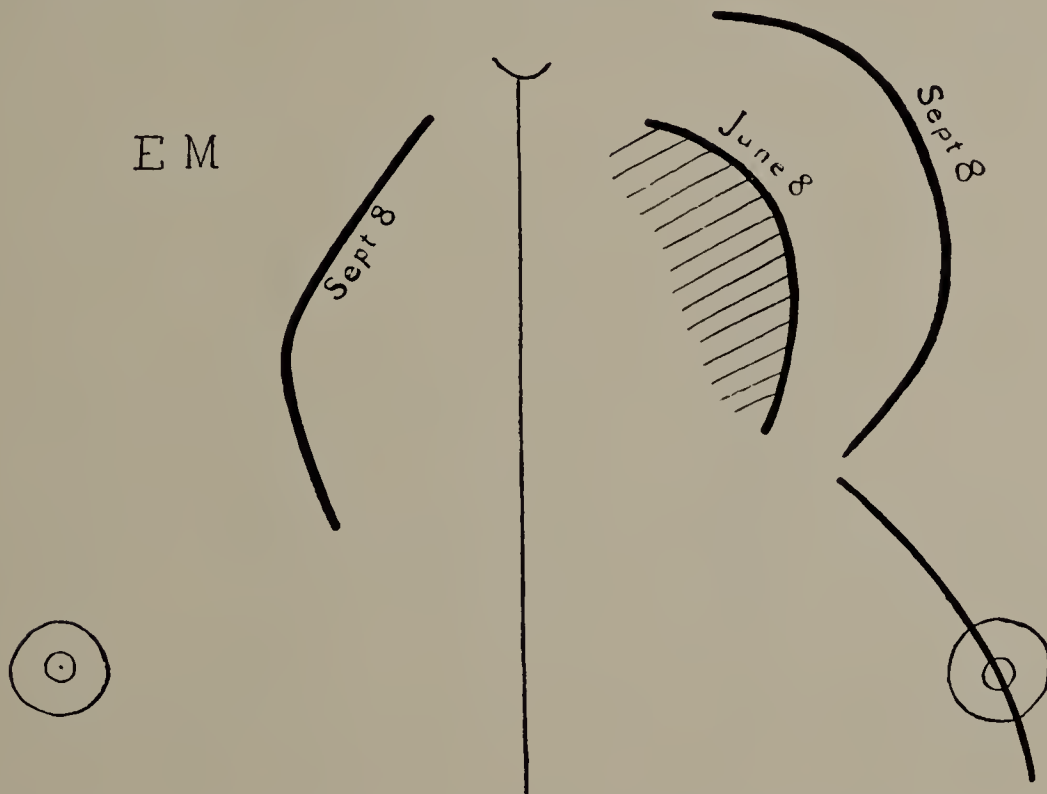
Case V. E. M. Cut of X-ray tracing. June 8, first X-ray examination. Small aneurism indicated by full line enclosing shaded area. September 8, second X-ray examination. Increase of aneurism indicated by full lines marked "Sept. 8." (Cut one-third original size.)
